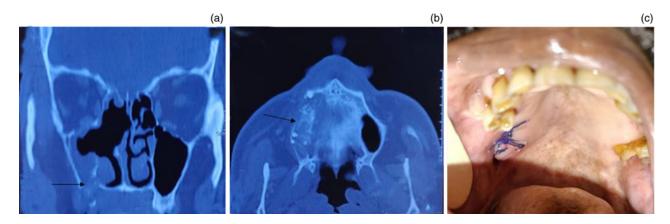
Case 4. Contrast-enhanced computed tomography of the nose, paranasal sinuses and orbit in the (a) coronal and (b) axial view. Black arrow indicates rightsided hard palate erosion. (c) Post-operative image.
